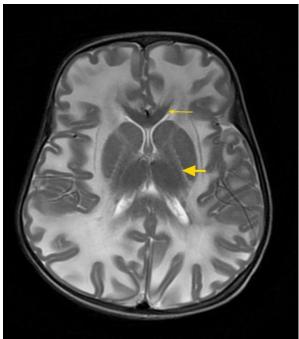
Axial T2 MRI showing sparing of internal capsule (thick arrow), corpus callosum (thin arrow).
